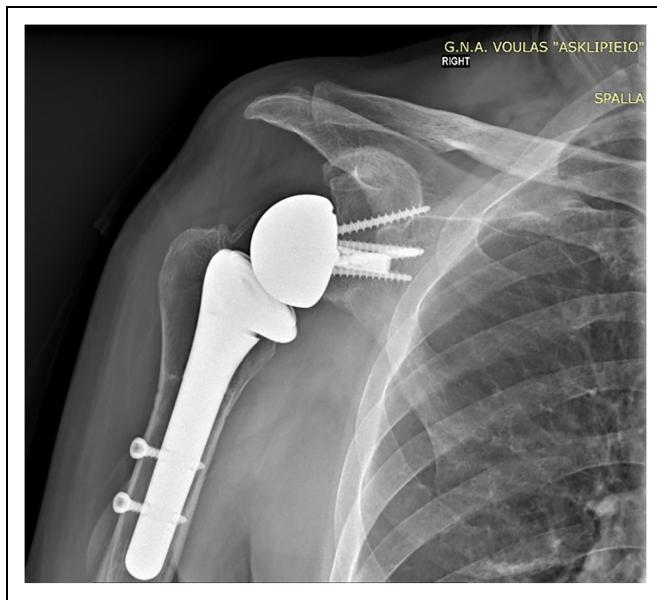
Anteroposterior radiograph of the right shoulder at 12 years after reverse total shoulder arthroplasty.
